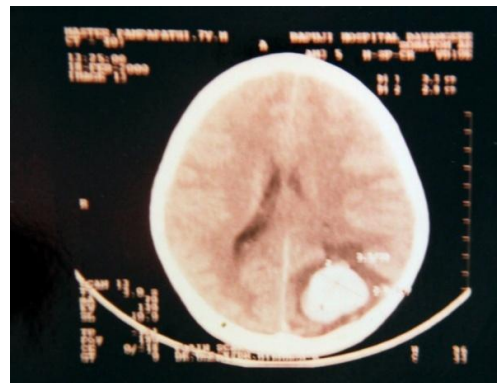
CT scan view of intracerebral hematoma
